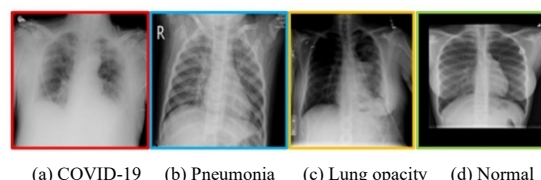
(A-D) Chest X-ray images collected from Kaggle dataset. Sample chest X-ray images of different classes in the dataset. The eyes of a non-expert human can hardly distinguish between the classes.
